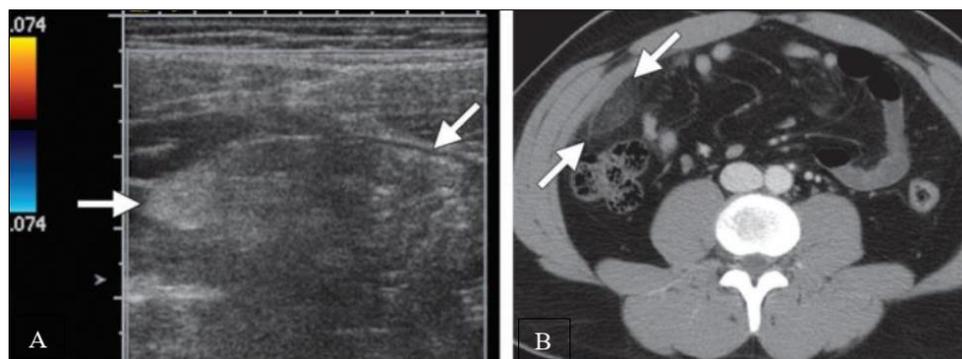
Omental infarction in a 21-year-old man with right-lower-quadrant pain. (A) Color Doppler US image of the right lower quadrant shows an ovoid area of avascular echogenic fat (arrows) that corresponds to the area of pain. (B) Axial CT image obtained on the same day as the US image shows an encapsulated fatty mass (arrows) adjacent to—but separate from—the ascending colon, a finding indicative of right-lower-quadrant omental infarction [4].
